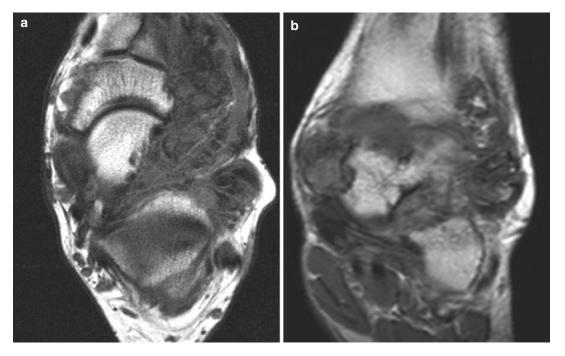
Pigmented villonodular synovitis (PVNS): (a) axial T1-weighted MR image; b) coronal T2-weighted MR image of the left ankle. There is a large intra-articular
